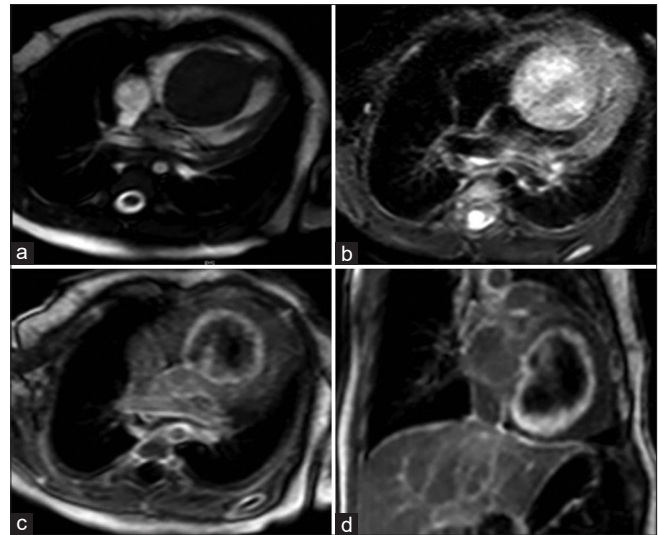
Cardiac magnetic resonance imaging. The cardiac magnetic resonance imaging showed a large solitary tumor confined at the IVS measuring 36 cm × 35 cm × 46 mm, occupying most of both ventricular cavities. The mass was homogeneously isointense on T1-weighted imaging (a), and slightly hyperintense on T2-weighted imaging (b), with no hypocaptant lesions inside. There was a heterogeneous hypercaptation in the external wall of the tumor, with internal hypocaptation in late gadolinium enhancement sequences (c and d)
